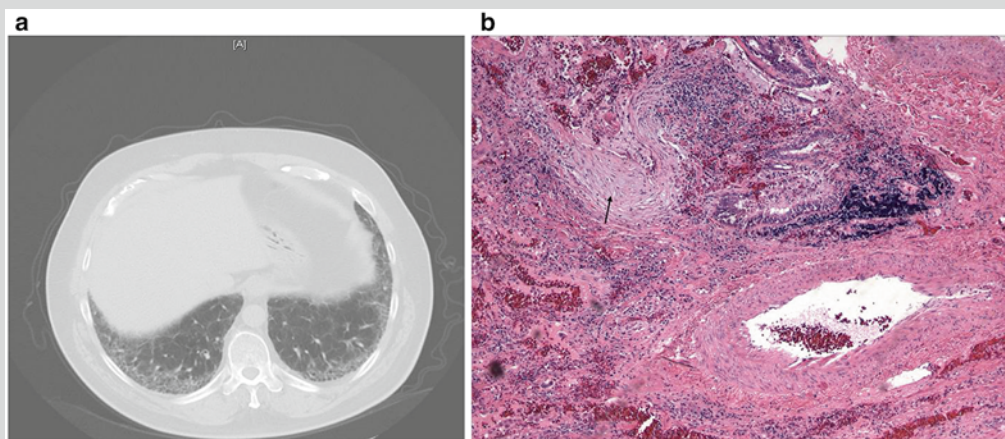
(a) HRCT shows honeycombing (arrows) with reticular changes at the bases of both lung fields. (b) Evidence of fibrosis and lymphocytic aggregates on lung biopsy with arrows noting a fibroblastic foci
